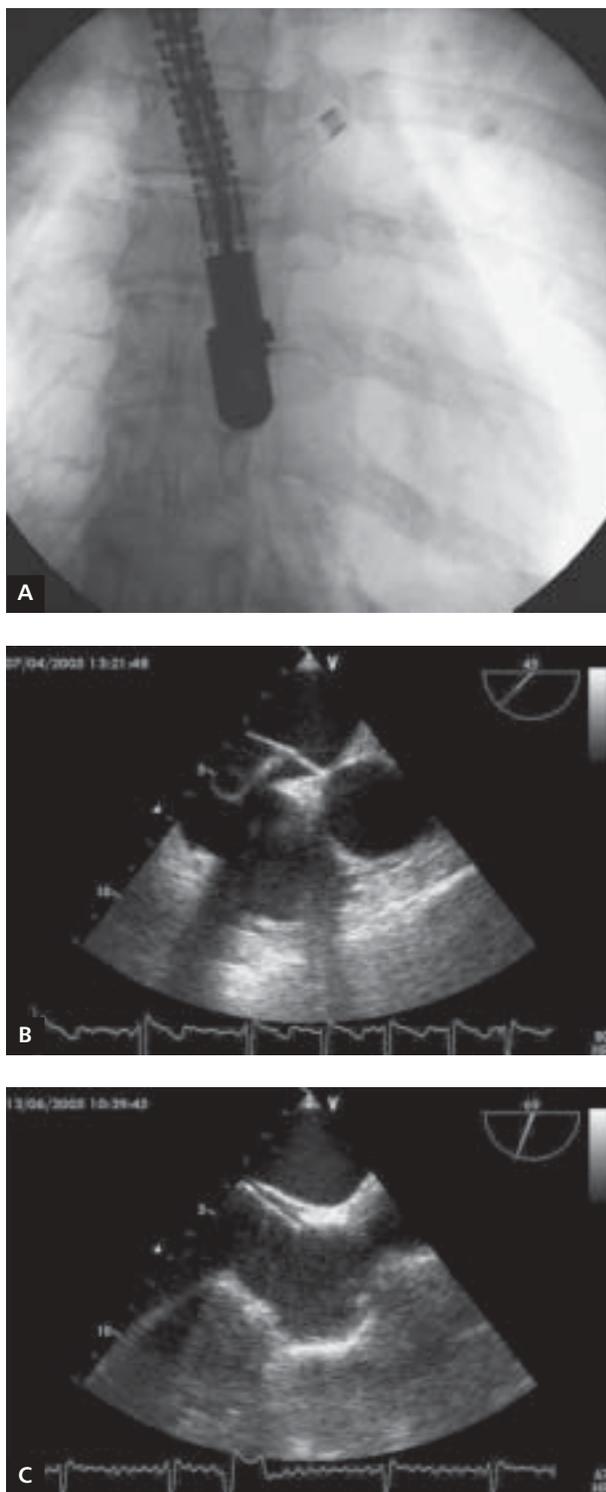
A. Transseptal sheath introduced via PFO to the left atrium; B. Left-sided Intrasept (CARDIA) occluder disc after opening in the left atrium on trans-oesophageal echocardiography (TEE); C. Intrasept occluder sealing the PFO immediately after implantation (TEE)
